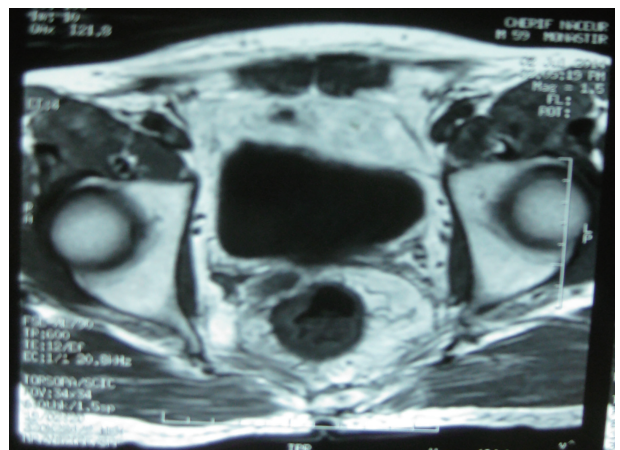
Magnetic resonance imaging after chemoradiotherapy.
